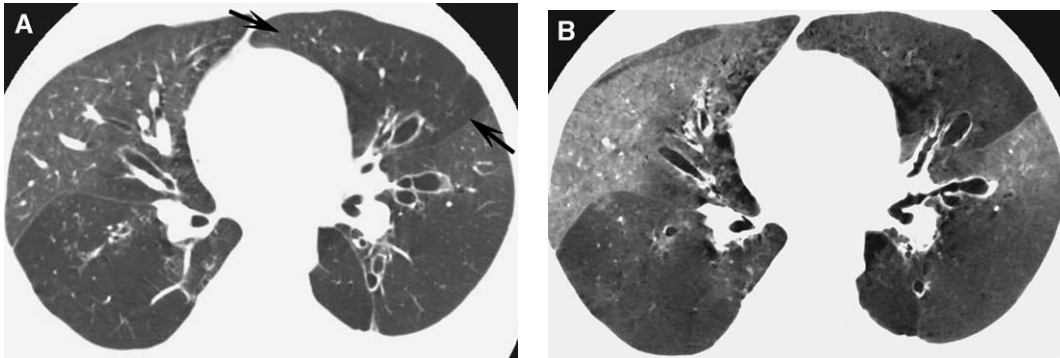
Inhomogeneous lung opacity: mosaic perfusion in a patient with bronchiectasis. (A) Axial HRCT image shows central bronchiectasis with multifocal, bilateral inhomogeneous lung opacity, particularly in the left upper lobe (*arrows*), left lower lobe, and right lower lobe. Note how the vessels within the areas of abnormally low attenuation are smaller than their counterparts in areas of normal lung attenuation. (B) Axial minimum intensity projected image shows the multifocal mosaic perfusion to advantage.
